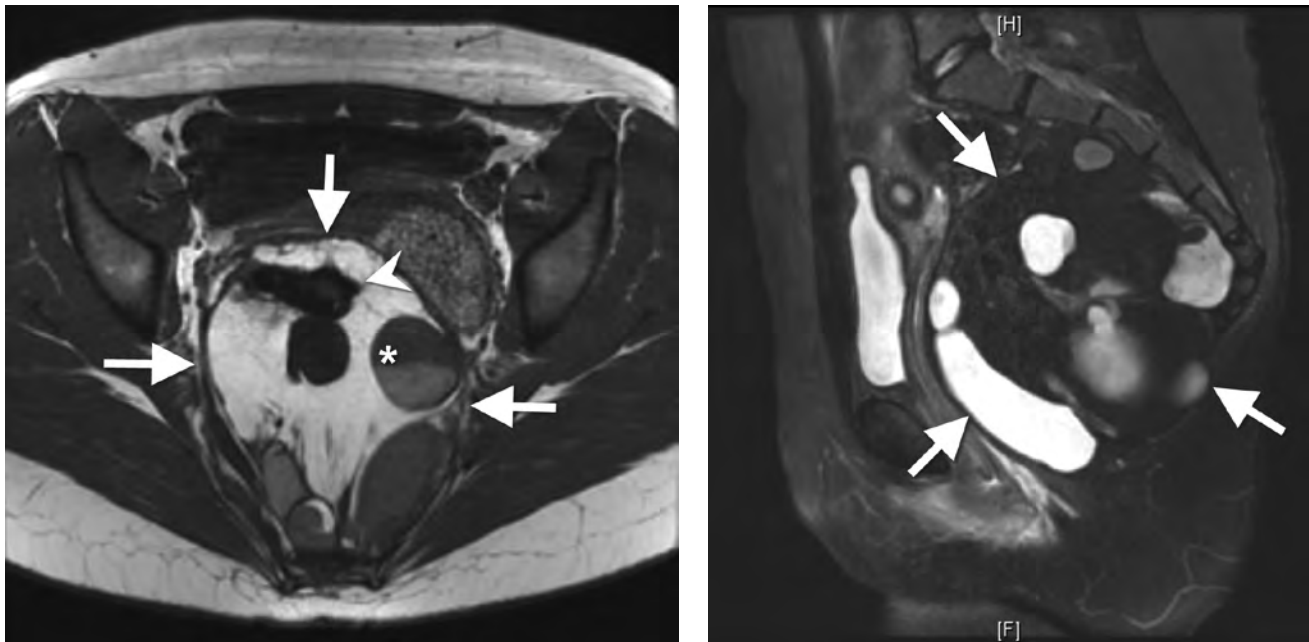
A. Axial T1 Spin Echo, B. Sagittal T2 Fat Saturated (FS) Fast Spin Echo MR images of the pelvis show a large heterogeneous presacral mass (arrows). The mass shows a component with fluid-fluid level (asterisk) and calcified component (arrowhead).
